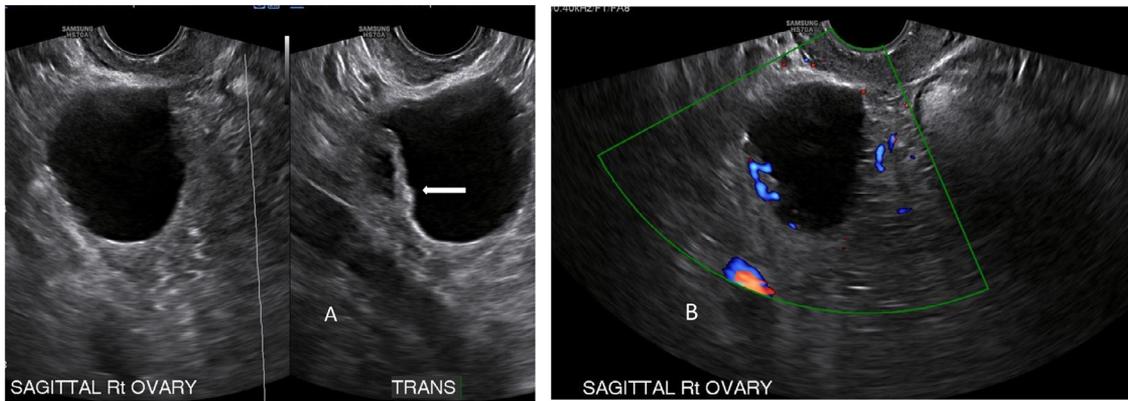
(A) Unilocular cystic right ovarian tumor with solid components (arrow). (B) Color Doppler image shows moderate vascular flow within the solid components.
